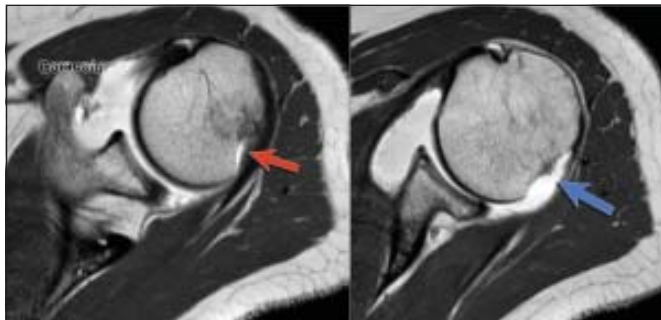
MRI: Hill-Sachs lesion in posterolateral part of the head of the humerus
